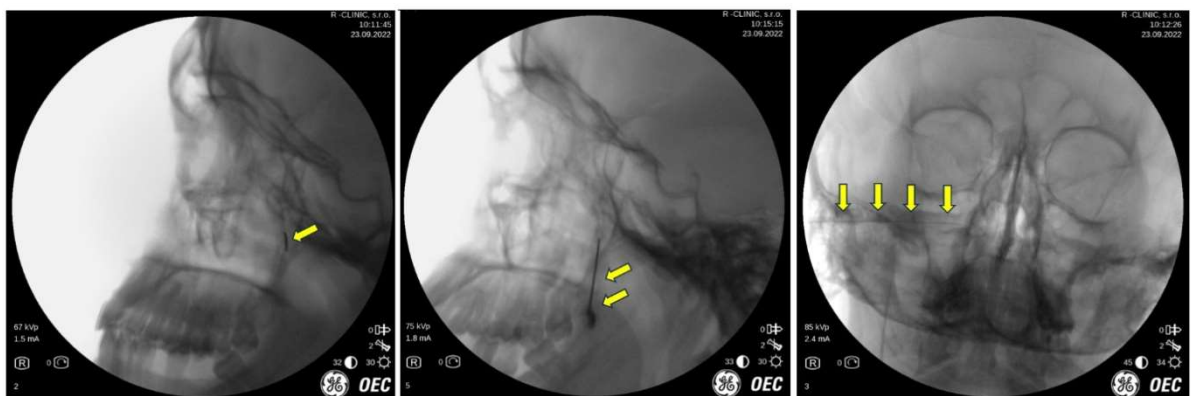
Interventional procedure of the sphenopalatine ganglion blockade under X-ray navigation in lateral and AP projection (from the author's archive).
